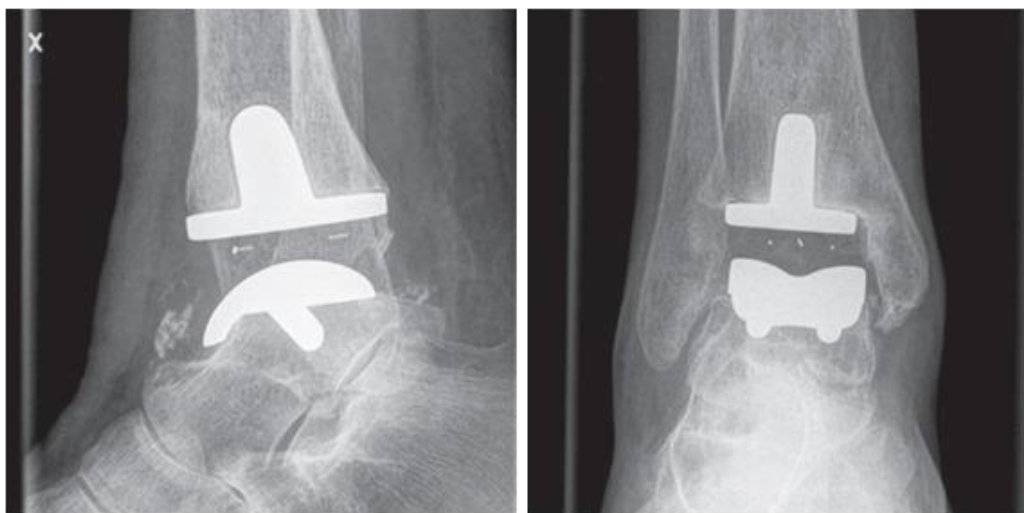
X-ray of the Rebalance ankle. Side view (left) front view (right). This design has been used in Sweden since 2011
